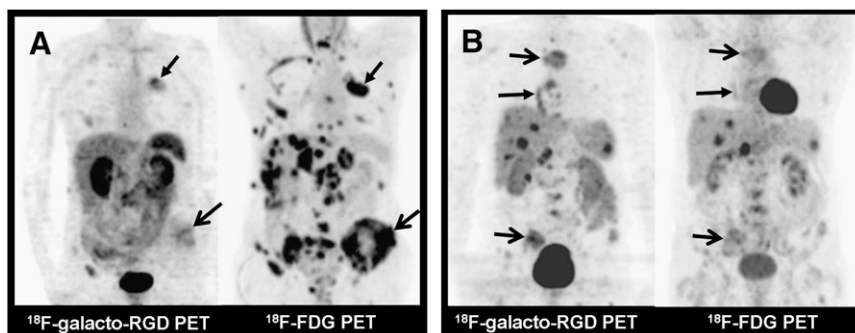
Comparison of different uptake patterns in ^{18}F -FDG PET and ^{18}F -galacto-RGD PET. (A) Patient with NSCLC of left upper lobe (arrow, closed tip) and multiple metastases to bone (arrow, open tip), liver, lymph nodes, and adrenal glands. Note intense uptake in all lesions in maximum-intensity-projection (MIP) of ^{18}F -FDG PET, whereas uptake in lesions in MIP of ^{18}F -galacto-RGD PET is substantially lower. This typical uptake pattern is seen in most patients. (B) Patient with neuroendocrine tumor of bronchus in right lower lobe (arrow, closed tip) and multiple metastases to bone (arrows, open tip), liver, spleen, and lymph nodes. This patient shows more intense uptake in lesions on ^{18}F -galacto-RGD PET compared with that on ^{18}F -FDG PET.
